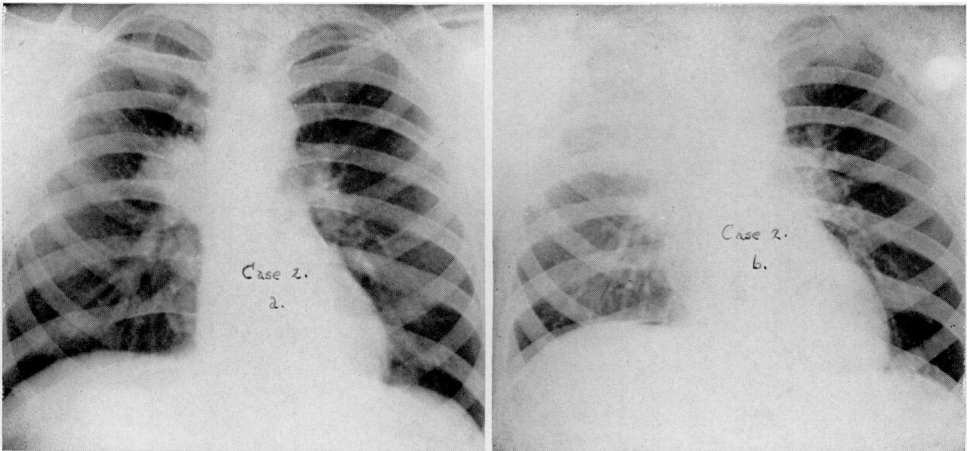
(Case II). X-rays taken on the fourth day of disease (a) and on the seventh day (b), showing the development of a lesion at the apex.
